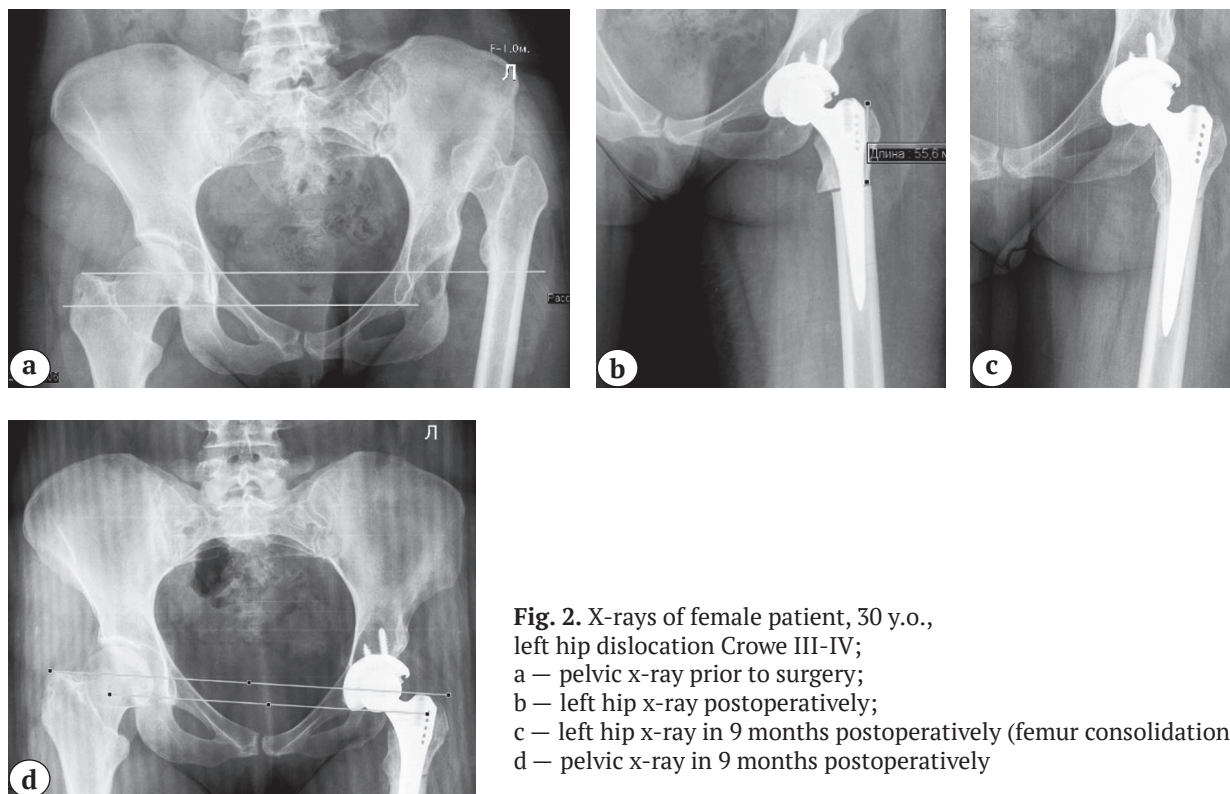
X-rays of female patient, 30 y.o., left hip dislocation Crowe III-IV; a — pelvic x-ray prior to surgery; b — left hip x-ray postoperatively; c — left hip x-ray in 9 months postoperatively (femur consolidation); d — pelvic x-ray in 9 months postoperatively
